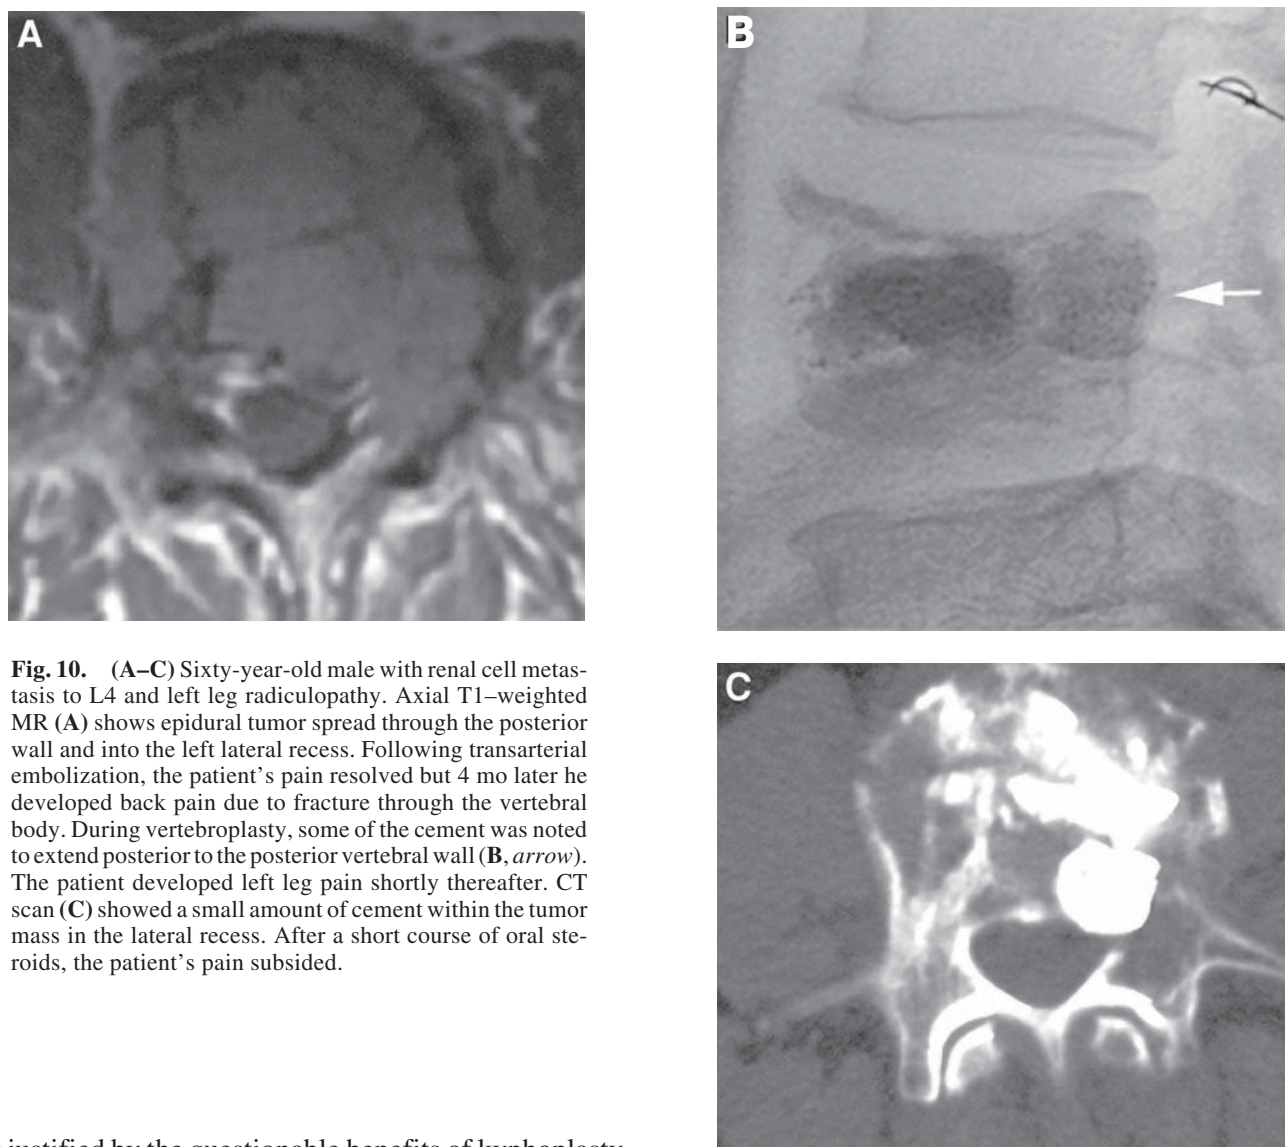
(A–C) Sixty-year-old male with renal cell metastasis to L4 and left leg radiculopathy. Axial T1-weighted MR (A) shows epidural tumor spread through the posterior wall and into the left lateral recess. Following transarterial embolization, the patient's pain resolved but 4 mo later he developed back pain due to fracture through the vertebral body. During vertebroplasty, some of the cement was noted to extend posterior to the posterior vertebral wall (B, *arrow*). The patient developed left leg pain shortly thereafter. CT scan (C) showed a small amount of cement within the tumor mass in the lateral recess. After a short course of oral steroids, the patient's pain subsided.
